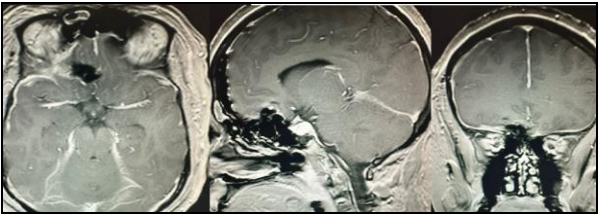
The MRI showing postoperative surgical excision of the tumor.
